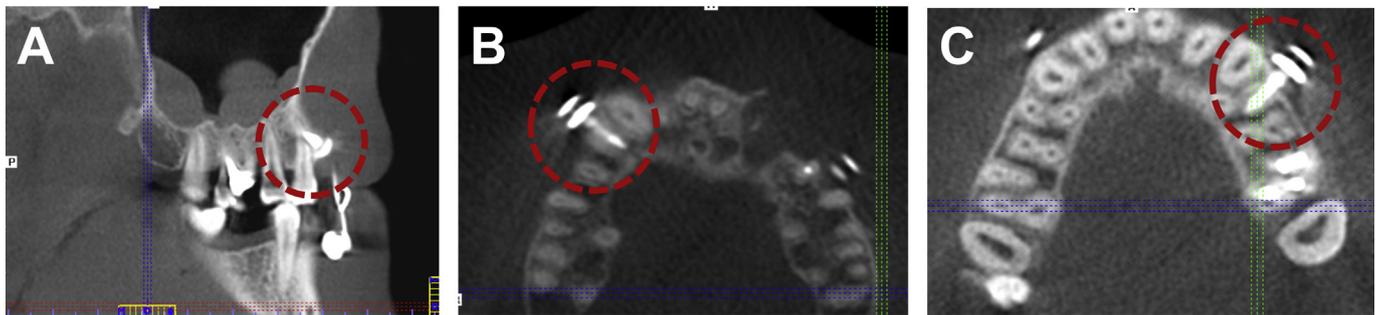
CBCT examples of the different grades of severity of tooth root injuries. (A) grade 1: root scratch of the first premolar of the right upper jaw (red circle), (B) grade 2: severe injury without damage of the dental pulp of the first premolar of the right upper jaw (red circle), (C) grade 3: severe injury with damage of the dental pulp of the first premolar of the left upper jaw (red circle).
